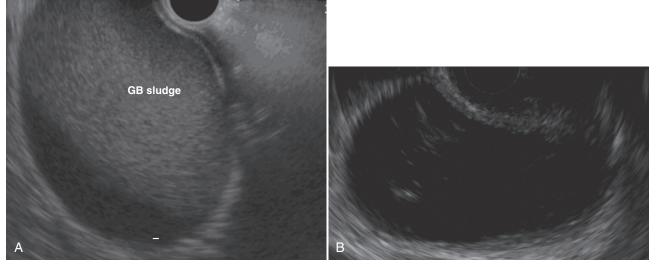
Gallbladder sludge missed on other image. A, Extensive sludge in the gallbladder (GB) on linear EUS (7.5 MHz) in a patient with acute idiopathic pancreatitis. Gallbladder sludge was missed on computed tomography scan and magnetic resonance imaging. B, Mobile, nonshadowing 1-mm reflections, seen on linear EUS (7.5 MHz), appreciated only after external palpation and shaking of the gallbladder (by pressing on the right upper quadrant of the abdomen).
